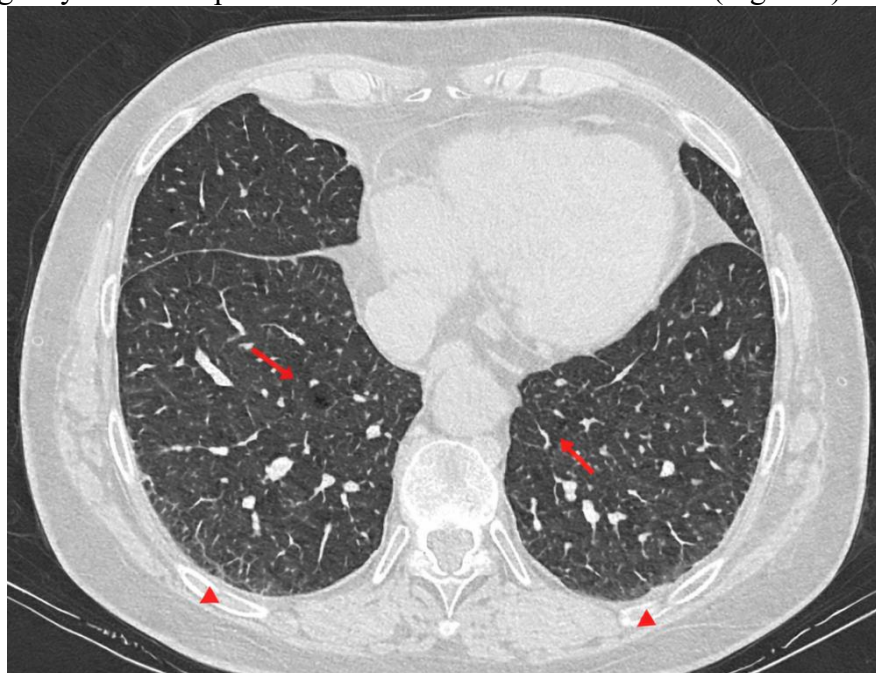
High-resolution computed tomography features of chronic interstitial lung involvement in systemic lupus erythematosus.
